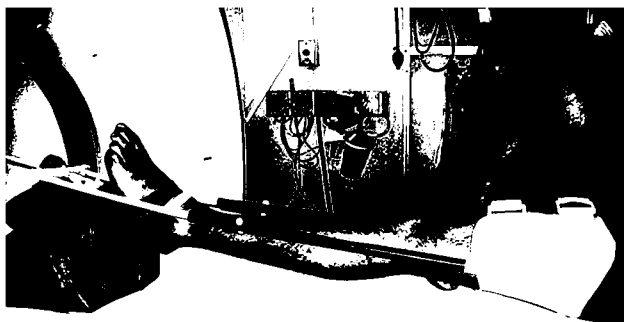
Patient leg with distractor in place prior to CT imaging.
